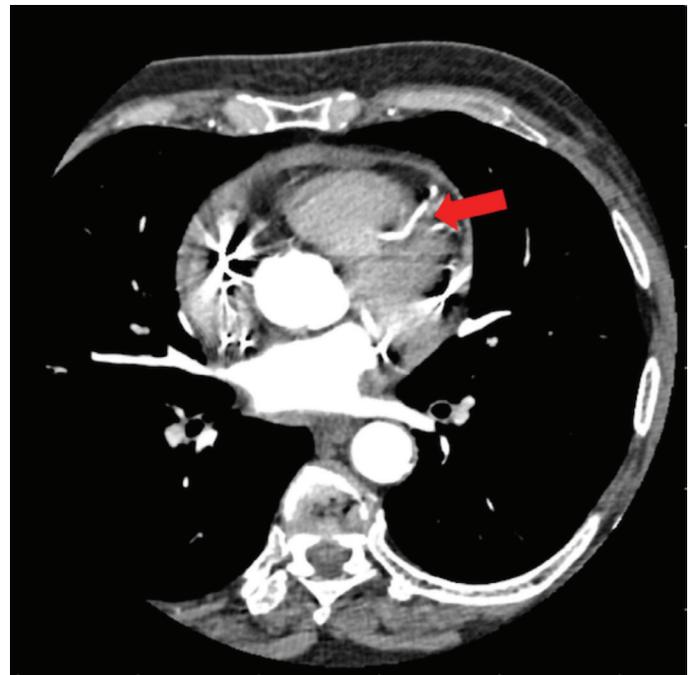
Cardiac CT (axial view) demonstrates a CRT lead that has perforated the right ventricle (red arrow)
